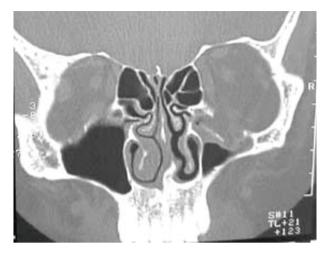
Multi-slice computed tomography scan - coronal slice.
